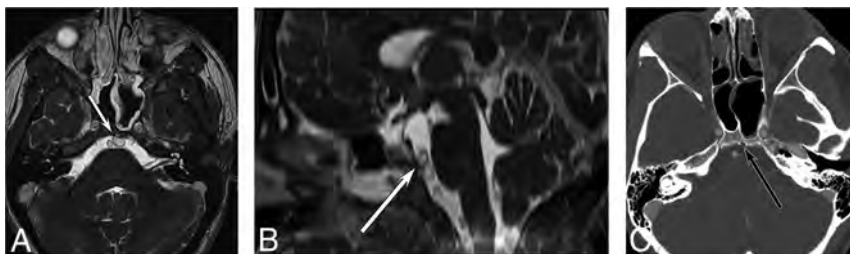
Follow-up imaging 4 years later. Axial steady-state free precession MR imaging (A) shows increased lesion size (arrow) with new involvement of the clivus. Sagittal reformat (B) shows increased superior-inferior extent. The clival involvement is confirmed on axial contrast-enhanced CT (C).
